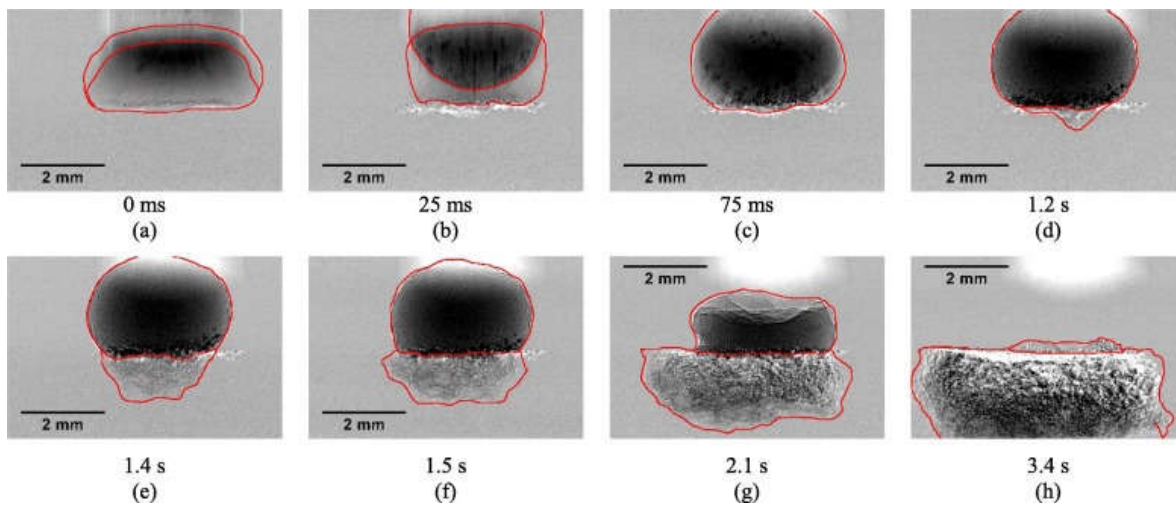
Time sequence X-ray images of dynamic wetting and nucleation process of APAP powders.
